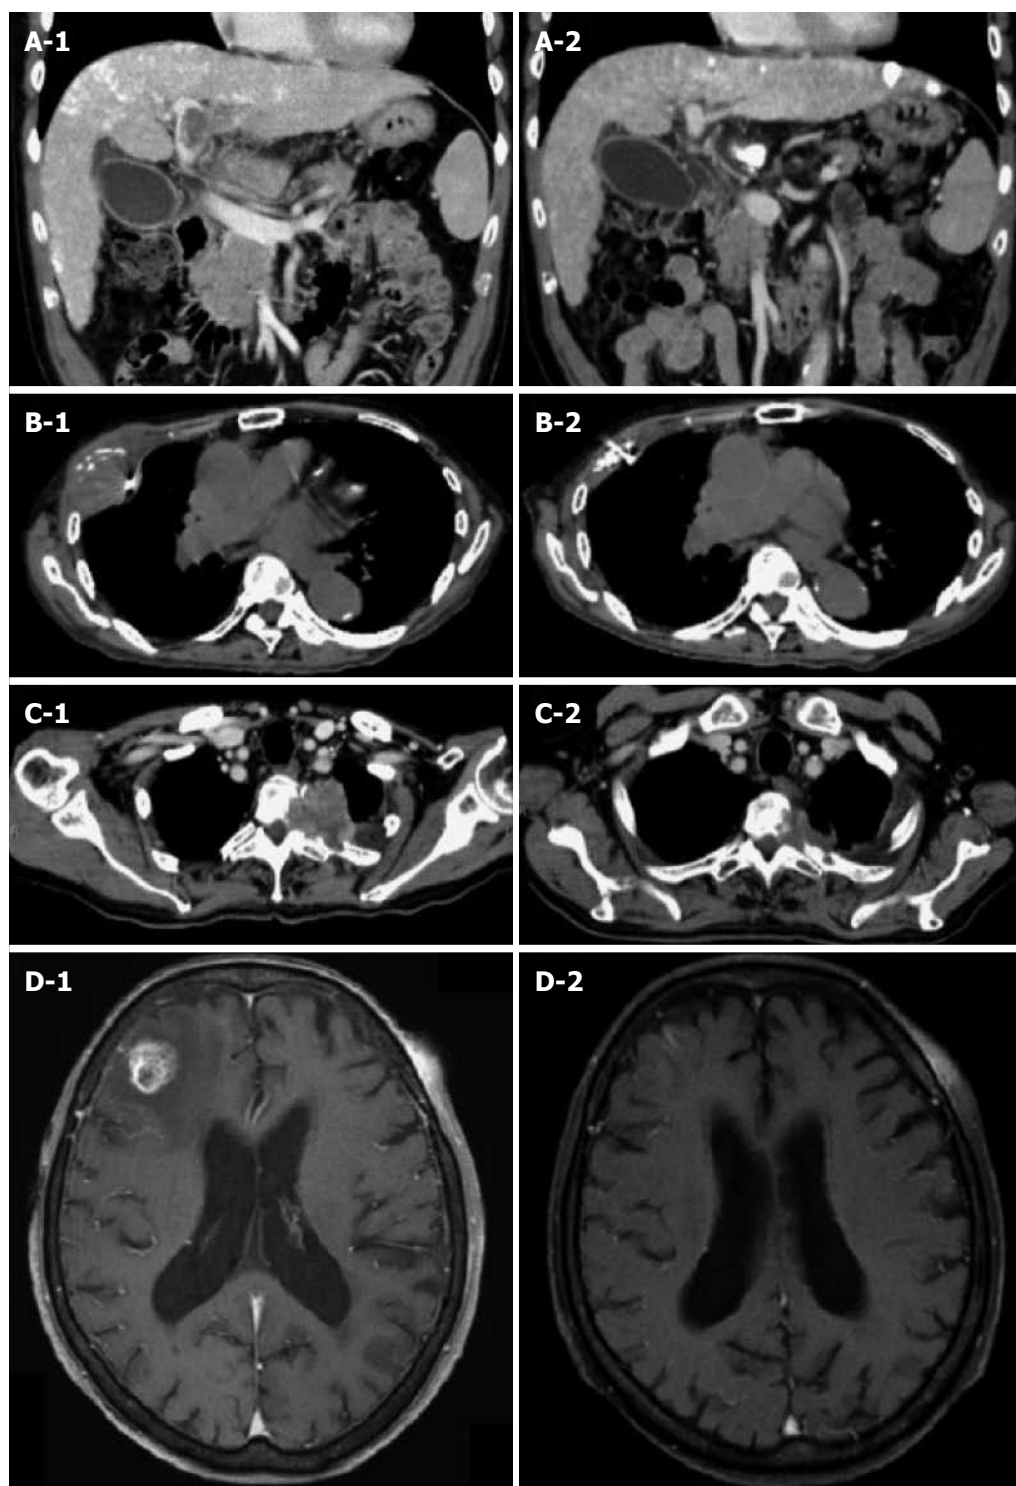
Tumor responses treated with Cyberknife. A1: CT scan of 59-year-old male with portal vein tumor thrombosis. The tumor is invading the portal vein from the main trunk to the 1st branch. The tumor diameter was 46 mm. A fiducial marker was implanted nearby; A2: Three months after irradiation with 35 Gy/5 fractions. The portal vein tumor thrombosis disappeared completely and the patient achieved CR; B1: CT scan of 85-year-old male with pleural HCC metastasis. The tumor diameter was 53 mm. A fiducial marker was implanted nearby; B2: Three months after irradiation with 30 Gy/5 fractions. The tumor disappeared completely and the patient achieved CR; C1: CT scan of 72-year-old male with thoracic spine HCC metastasis. Tumor is invading the left side of the thoracic spine at T2-3 causing bone destruction. The tumor diameter was 52 mm; C2: Three months after irradiation with 30 Gy/5 fractions. The tumor decreased to 33 mm (37% reduction in size) and the patient achieved PR; D1: T1-weighted MRI of 83-year-old female with brain HCC metastasis. There is a right frontal lobe lesion with gadolinium enhancement. The tumor diameter was 19 mm; D2: One month after irradiation of 20 Gy/1 fraction. The tumor disappeared completely and the patient achieved CR. CR: Complete response; CT: Computed tomography; HCC: Hepatocellular carcinoma.
